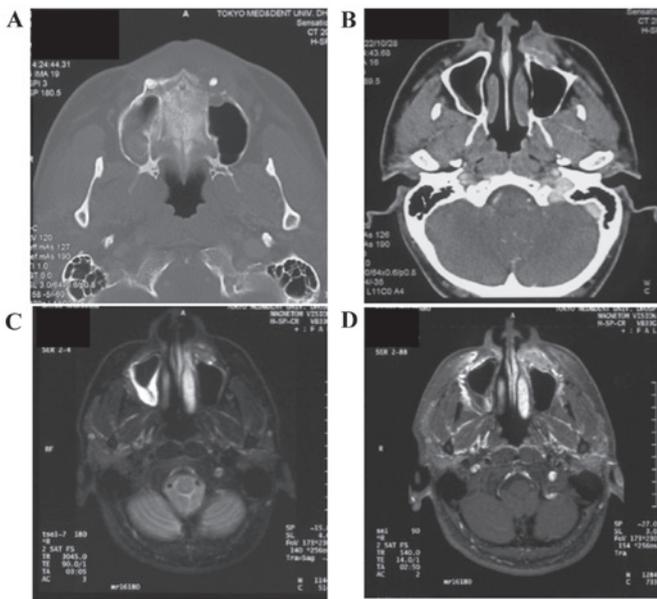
(A and B) Contrast-enhanced (CE) computed tomography (CT) and (C and D) CE-magnetic resonance imaging (MRI). (A) Axial CT image showing a soft tissue mass (30x16x22 mm³) with irregular borders. (B) The lesion exhibited heterogeneous density, invading and damaging the left lateral nasal wall and left bottom edge of the left maxillary sinus. (C) Axial MRI showing a high-density on a T2-weighted image, indicating expansion of the tumor to the base of the left nasal ala. (D) The lesion exhibited gadolinium enhancement.
